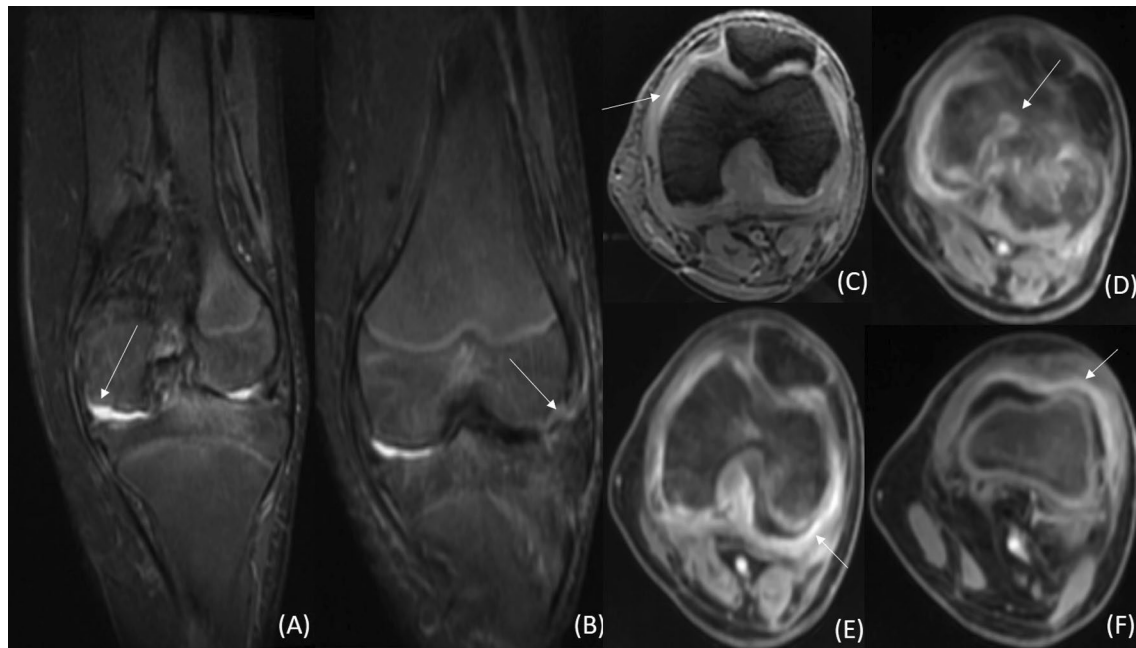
Tubercular knee arthritis. MRI of a 16-year-old girl shows erosions in medial and lateral femoral condyles on coronal STIR images (white arrow in A and B), there is mild joint effusion and marrow oedema in tibial plateau and intercondylar notch. Synovial thickening is seen on T2*GRE image (white arrow in C), T1 contrast-enhanced axial images show rim enhancement of the erosion (white arrow in D) and uniform synovial enhancement and thickening (white arrow in E and F)
